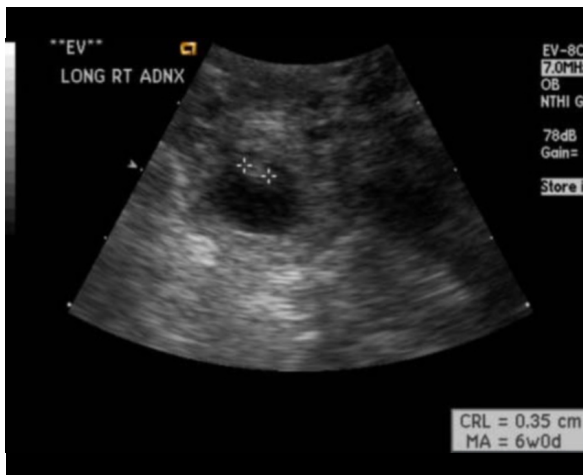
Transvaginal ultrasound of the right adnexa showing an ectopic pregnancy with a CRL of 3.5 mm corresponding to a gestational age of 6 weeks 0 days.
